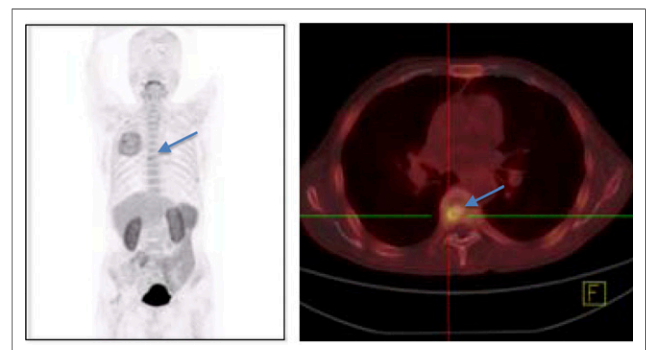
^{18}F -alfatide PET and corresponding PET/CT image of lung cancer patient with bone metastasis (patient 4 in Table 1). (Left) Maximum-intensity-projection whole-body PET image. (Right) Transaxial PET/CT image covering bone metastatic lesion, 1 h after injection of ^{18}F -alfatide. Arrows point to bone metastatic lesion.
